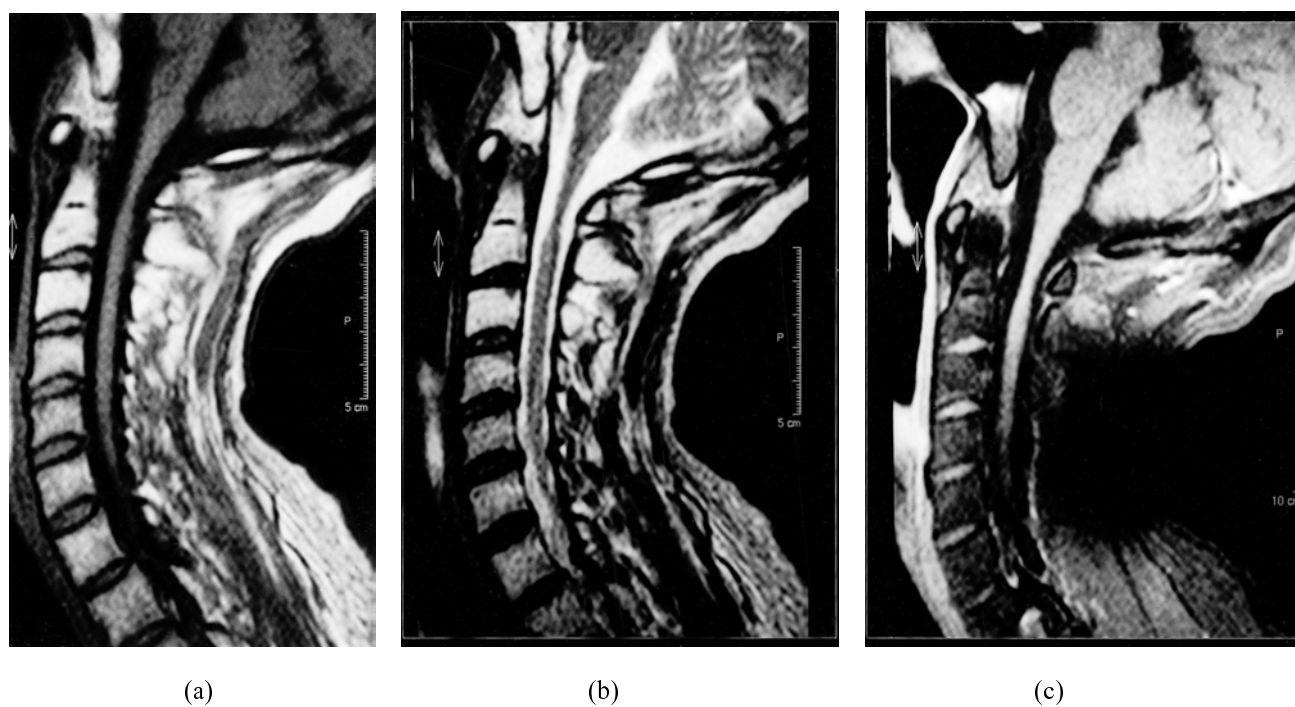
C-spine MRI in January 2000. a: Cord atrophy was showed at C1-3 level on sagittal T1WI. b: No obvious signal change at atrophic cord on T2WI. c: No enhancement at atrophic cord on post-contrast enhanced T1WI.
